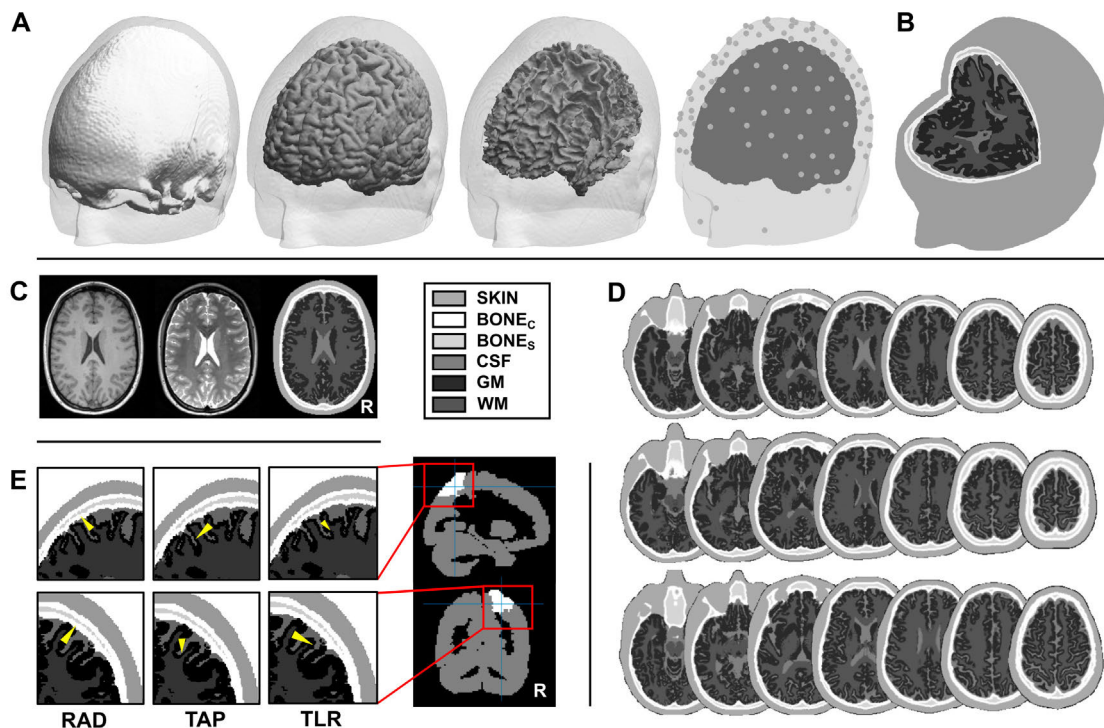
A) Isosurfaces of $BONE_C$, GM and WM compartments (from left to right), plotted within the transparent SKIN compartment for one exemplary participant. Aligned electrode positions of the 126-channel layout and, electro-oculogram electrodes, as well as fiducials are shown with respect to the GM surface and projected onto the SKIN surface. B) Complete head model showing all six compartments for the same exemplary subject (see legend for color-codes). C) Correspondence between T1 and T2 MR images with the 6C segmentation in an axial slice of the same participant shown in A) and B). D) Exemplary MRI segmentations of three participants in axial slices. E) Stimulation target orientations (yellow cones) plotted on the 6C segmented volume as a close-up of the target region of interest in right SPL. Right SPL is highlighted (white) on the overall volume that is represented by the AAL atlas. Compartments are labeled as SKIN: scalp, $BONE_C$: bone compacta, $BONE_S$: bone spongiosa, CSF: cerebrospinal fluid, GM: gray matter, WM: white matter.
